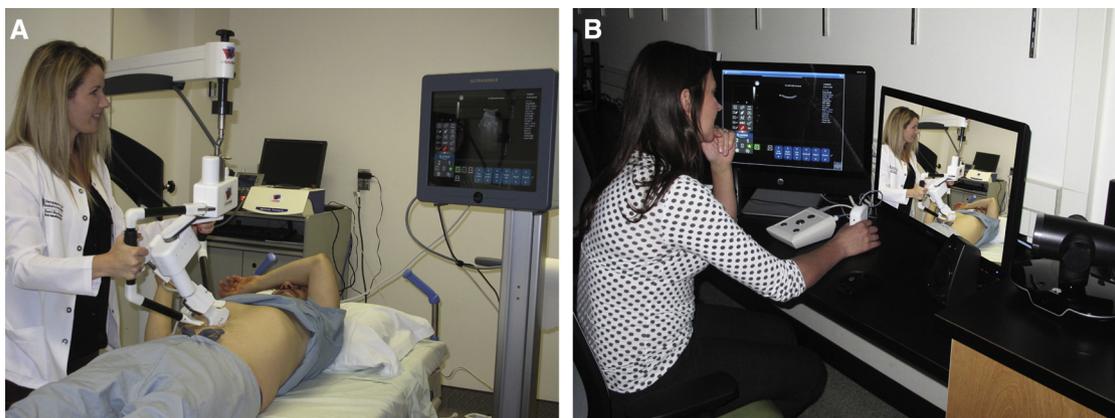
(A) At the patient site, an assistant holds the frame for the robotically controlled ultrasound transducer on the patient's abdomen. The videoconferencing system allows for communication between the sonographer and the patient and patient site assistant, enabling the patient site assistant to adjust pressure and gross placement of the robotic arm based on instructions from the sonographer. (B) At the sonographer site 2.75 km away, the sonographer manipulates a mock transducer; all movements of the mock transducer are replicated by the robotically controlled transducer at the patient site. The interface of the SonixTablet ultrasound system is displayed at the sonographer site, allowing the sonographer to scan in real time and control all ultrasound settings (image edited).
